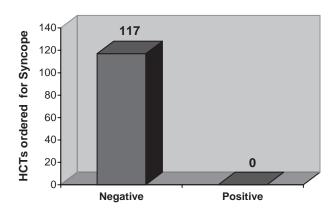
Primary results. HCT, head computed tomography.
